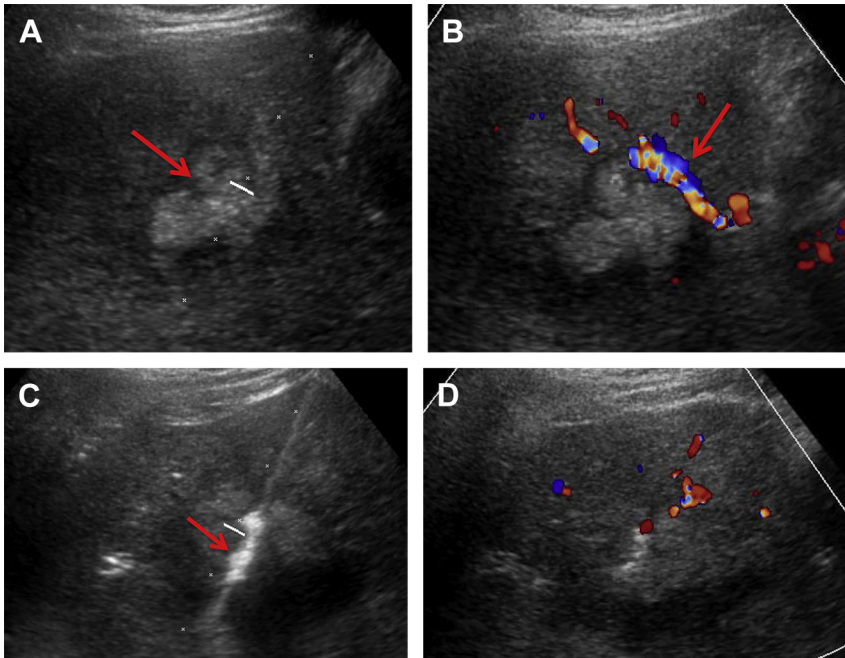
Necessary steps during a biopsy. (A) Assess trajectory to lesion (echogenic liver mass, *arrow*). (B) Apply color Doppler and look for vessels in the path (*arrow*). (C) Record each pass showing needle location (*arrow*). (D) Postscan with and without color Doppler to look for bleeding (none detected).
